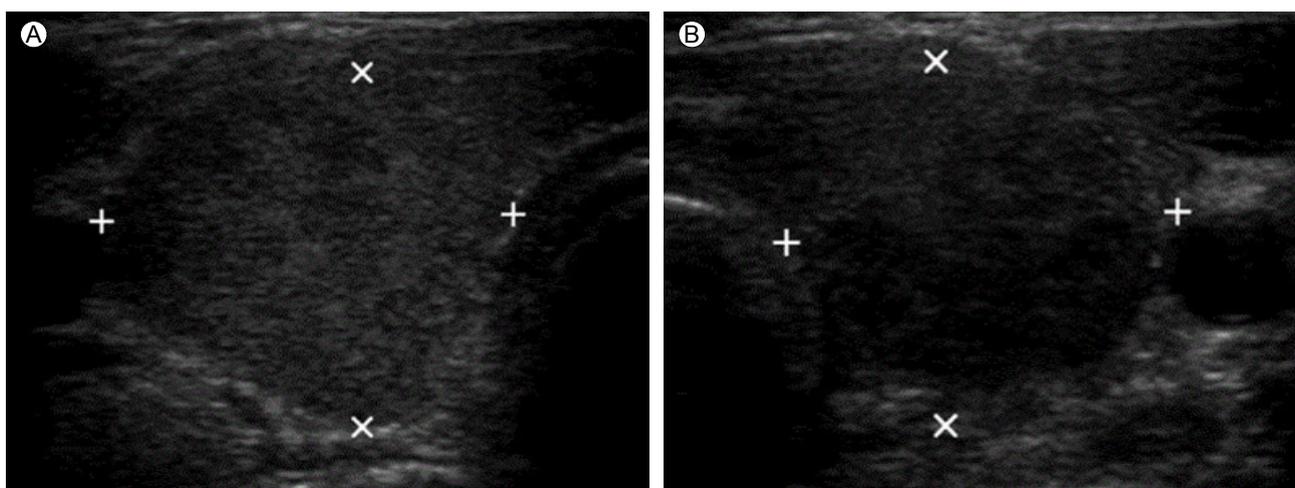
(A) and (B) Thyroid ultrasonography showed that both glands were enlarged (RT 2.23 \times 2.01 cm; Lt 1.93 \times 1.95 cm), and revealed hypoechogenicity and a heterogeneous structure.
